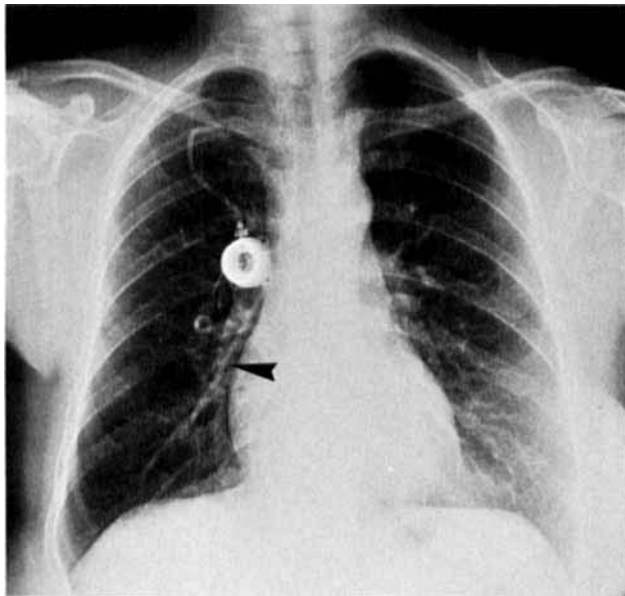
Case report 2. Chest radiograph 5 months following catheter insertion, showing a fracture of the silicon catheter with the distal portion embolized to the right pulmonary vein (arrow).
